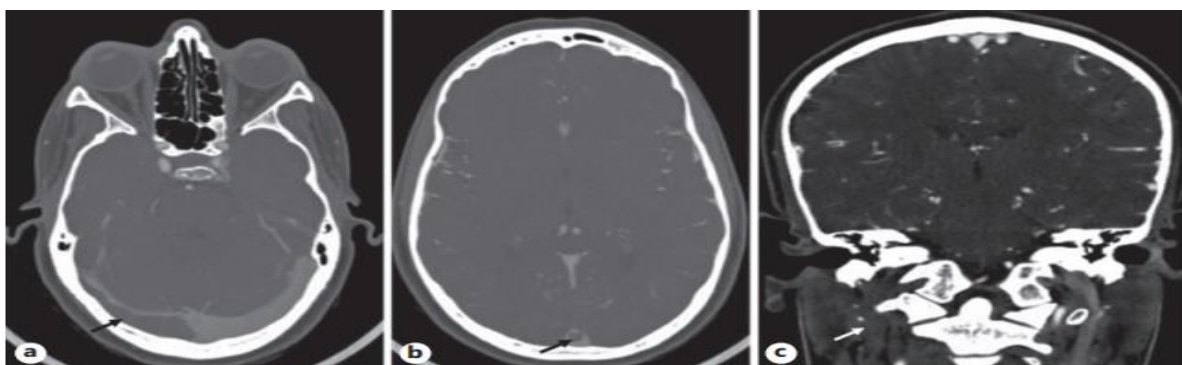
(a) Filling defect in the right jugular vein, sigmoid sinus, and transverse sinus found in, computed tomography angiography (CTA). (b) The superior sagittal sinus shows a classic empty delta sign. (c) Coronal image shows a filling defect in the right jugular vein with no evidence of venous dissection.
